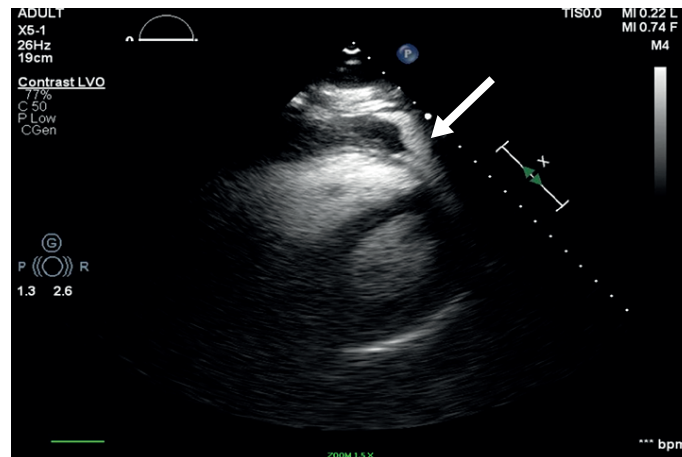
Transthoracic echocardiogram with Lumason ultrasound enhancing agent. Subcostal view showing large pericardial effusion with active Lumason extravasation (white arrow) into pericardial space consistent with right ventricular free wall perforation.
